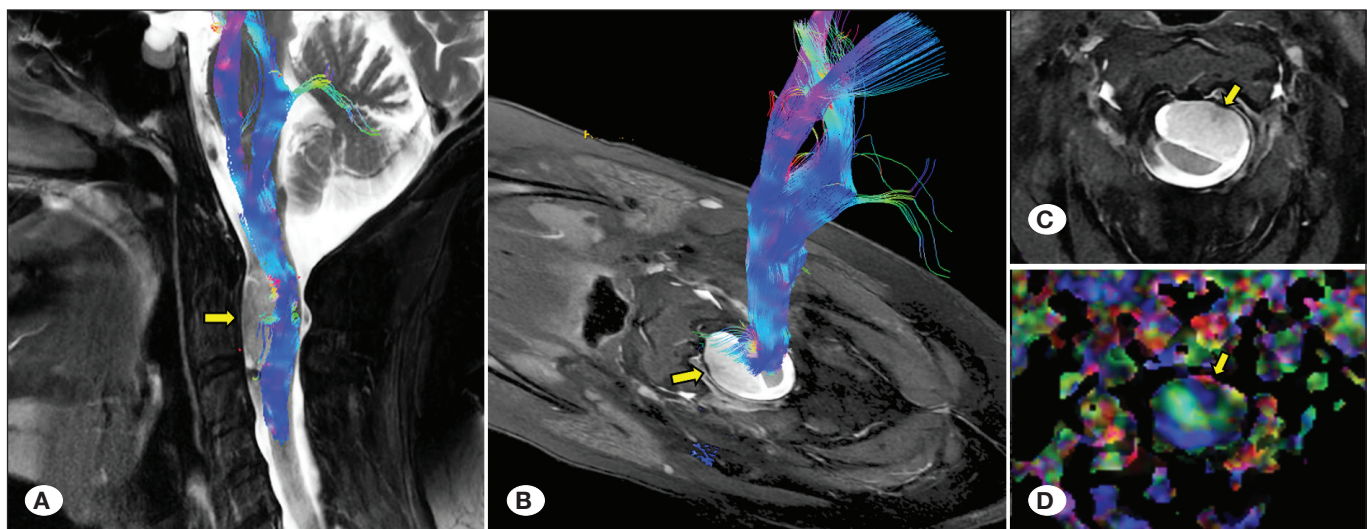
A 61-year-old woman with numbness in her extremities had a meningioma at C1–C2 (yellow arrows) causing displacement of spinal cord tracts. T2-weighted sagittal fat-saturated image (A), T2-weighted axial fat-saturated image with cervical cord tracts (B), T2-weighted axial fat-saturated image (C), and color-coded FA map (D).
